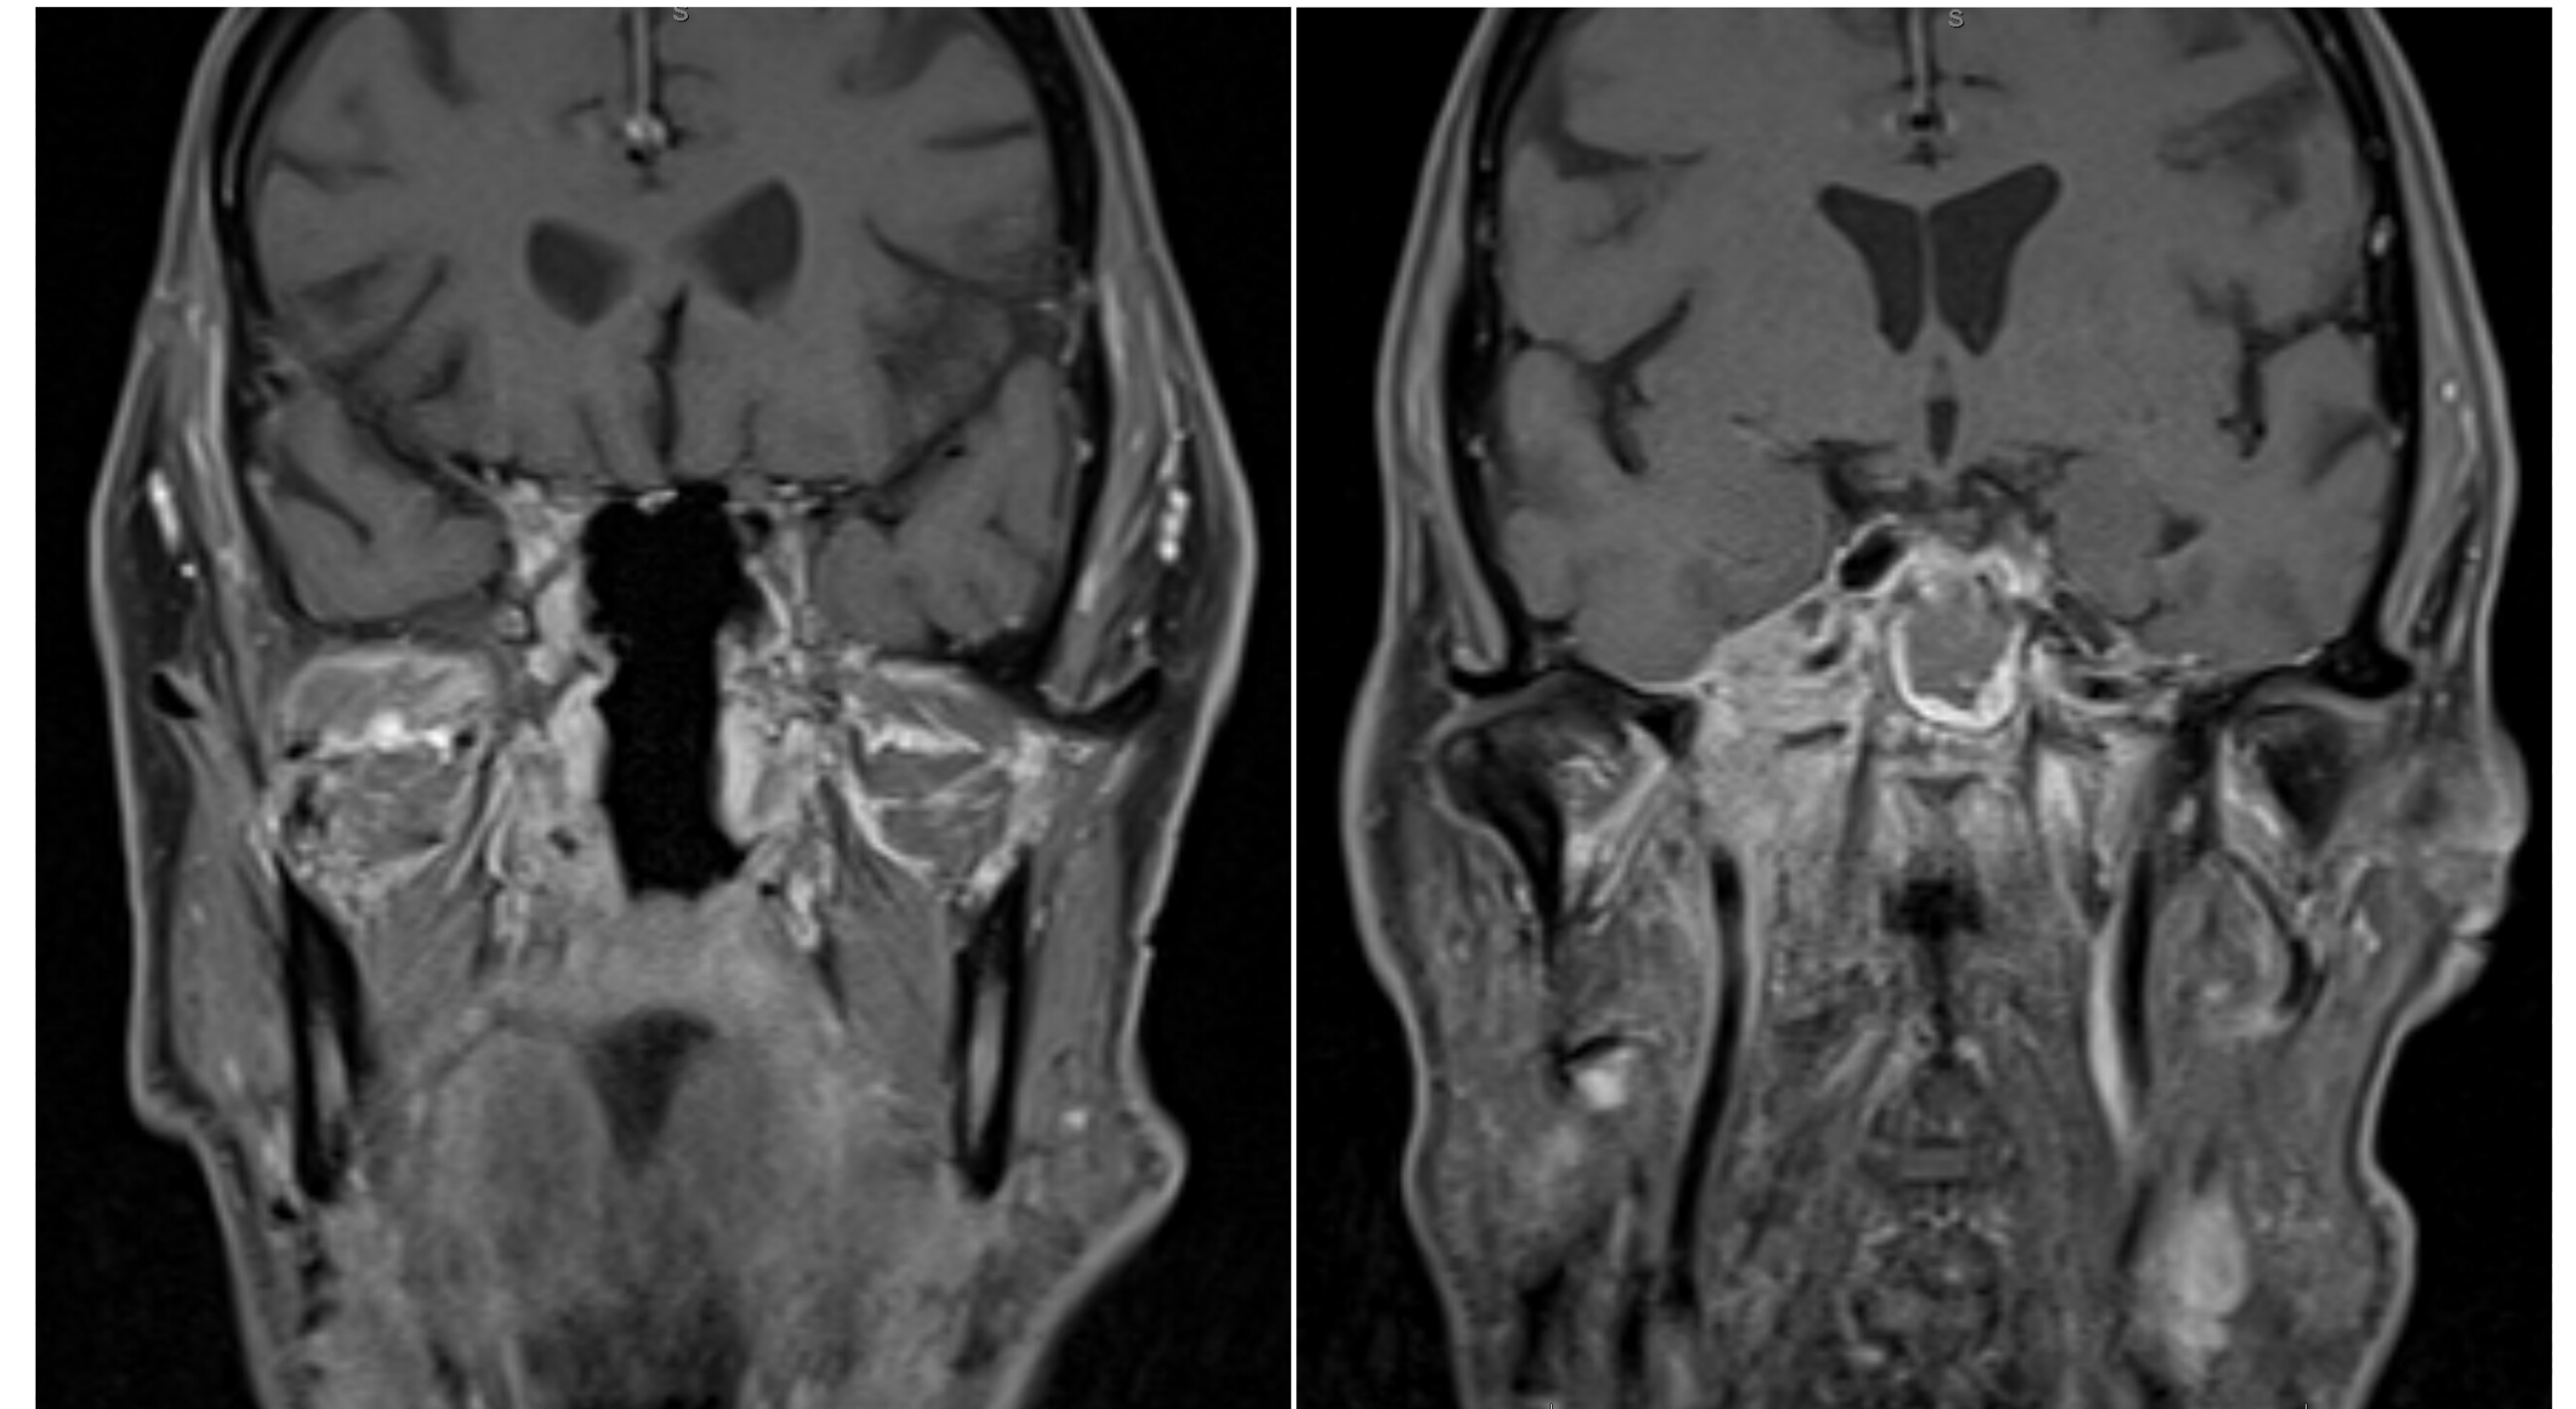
Postoperative MRI demonstrating right temporal lobe involvement and the extent of surgical dissection within the nasopharynx and sphenoid sinus.
